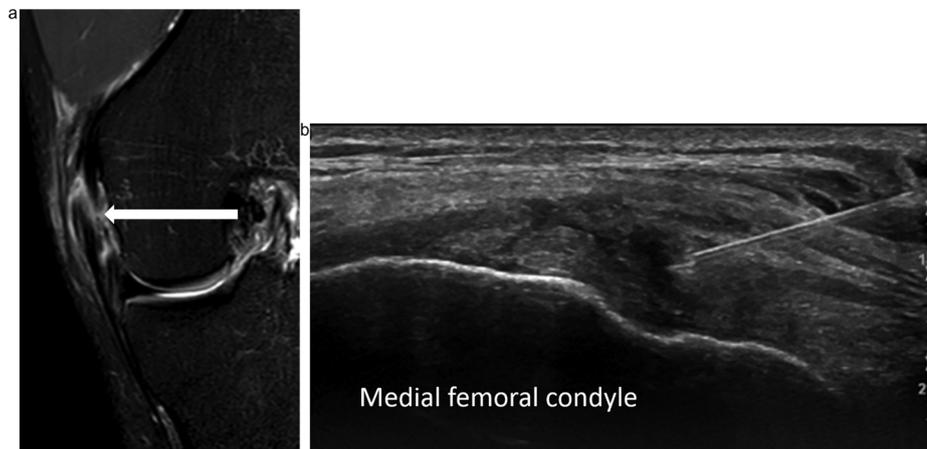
28-year old soccer player 4 weeks post injury to the medial collateral ligament. (a) Coronal STIR MRI demonstrating a tear through the superficial and deep band fibres of the medial collateral ligament. (b) Longitudinal sonogram demonstrating 23-gauge needle within the medial collateral ligament at the injury site. The ligament was injected with 3 ml of 25% glucose (1.5 ml 50% glucose in 1.5 ml 1% lidocaine).
